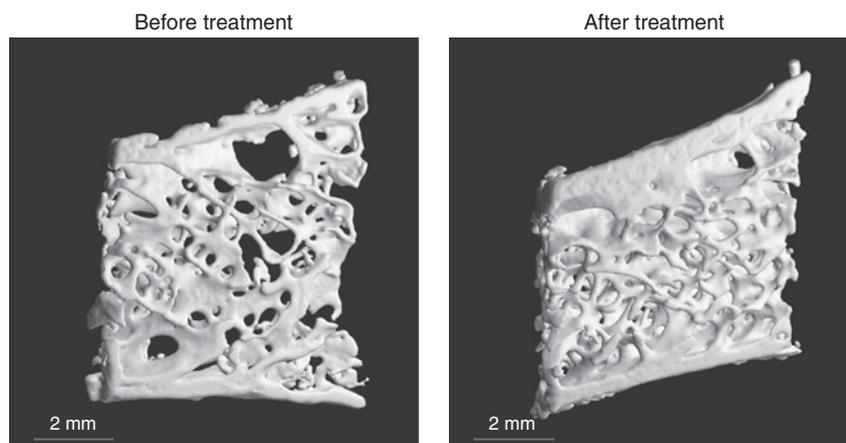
Microcomputed tomography images of paired biopsies from a 64-year-old woman before (Left) and after (Right) treatment with teriparatide. Note improvement in cancellous and cortical bone structure. (Reproduced from Dempster *et al.*, 2001, with permission).
